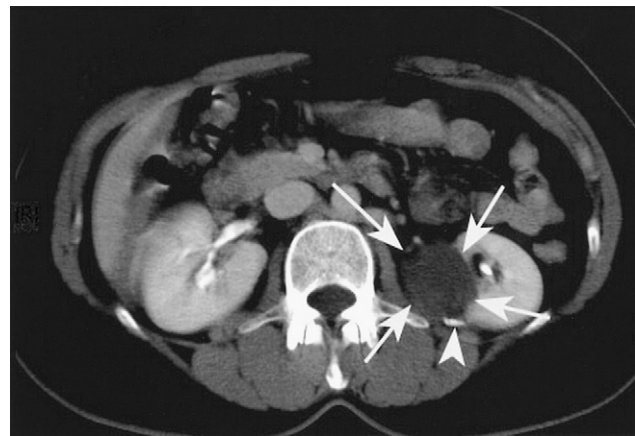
An abdominal computed tomography image with contrast shows a 3.7-cm cystic lesion (arrows) with a slightly irregular wall and calcification (arrowhead) in the left kidney. No enhancement is noted in the lesion after contrast medium injection. Complicated cyst should be considered.
